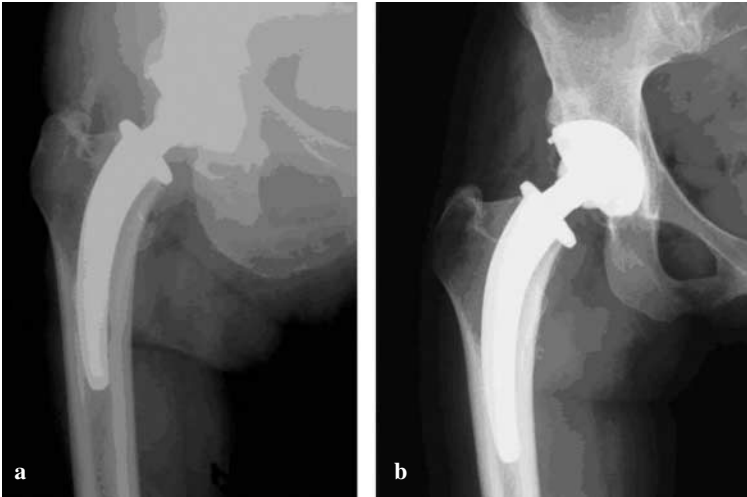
Good bone remodeling seen on anteroposterior radiographs of different patients who underwent total hip arthroplasty with the Link CFP stem. a Follow-up at 4 years. b Follow-up at 5 years
